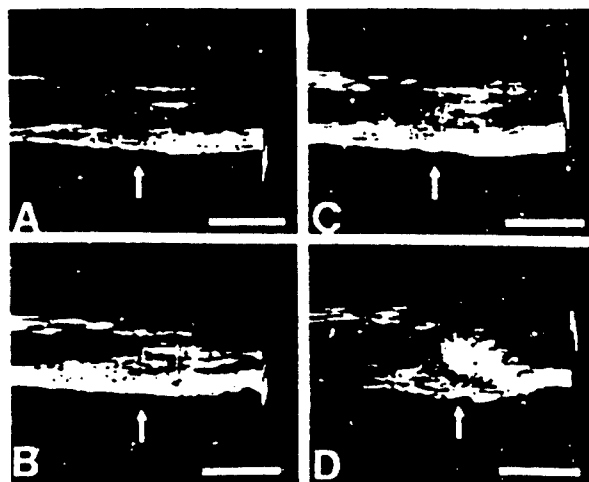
Ultrasound images obtained from a representative vessel during laser-heated-tip angioplasty. A: Atherosclerotic artery with central occlusion appearing as soft density. B: Laser-heated tip activated and advanced from the distal right-hand section. Increase in refractile density of plaque and vessel wall observed at the site of occlusion and distal to it. C: Laser-heated tip advanced through plaque with increased refractile density. D: Laser-heated tip advanced proximally and sparing the most proximal end of the occluding plaque. Magnification $\times 3$. Bar = 0.5 cm. Arrows indicate direction of ultrasound beam.
